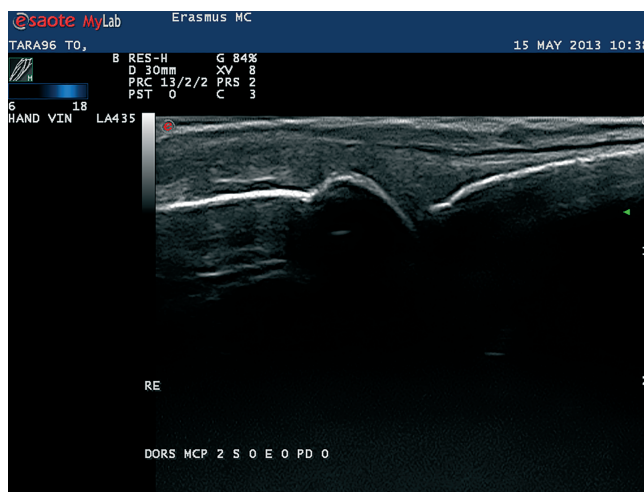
B-mode (grayscale) ultrasound image of an MCP2 joint. The white line on the right hand side of the image is the proximal phalanx; from the middle to the left is the caput of the metacarpal bone.
